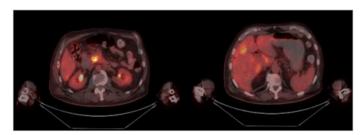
PET-CT - Pathological FDG uptake of pancreatic head and metastases at diagnosis.
